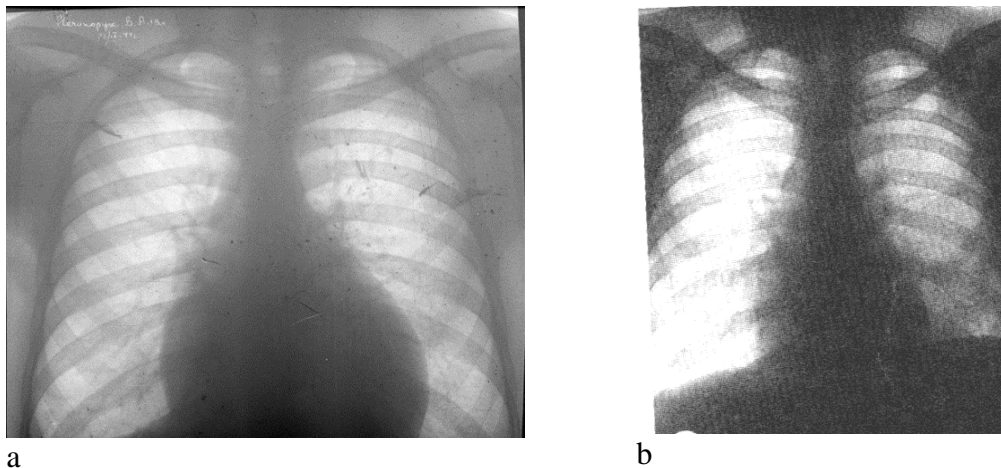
Chest X-ray showing hemopericardium resulting in pericardial tamponade. Heart shadow is distended, spherical (a), after pericardiocentesis it looks normal (b)
